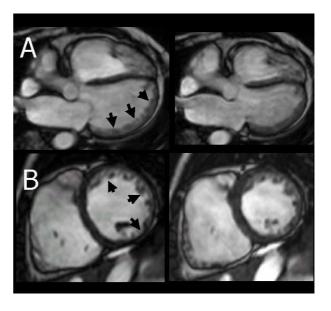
Cine magnetic resonance images showing a double-layered appearance in the lateral wall (*arrows*) on the 4-chamber view (A) and marked trabeculations and deep intratrabecular recessess in the anterior, lateral and inferior segments (*arrows*) on the short-axis view. Left = diastole, right = systole.
